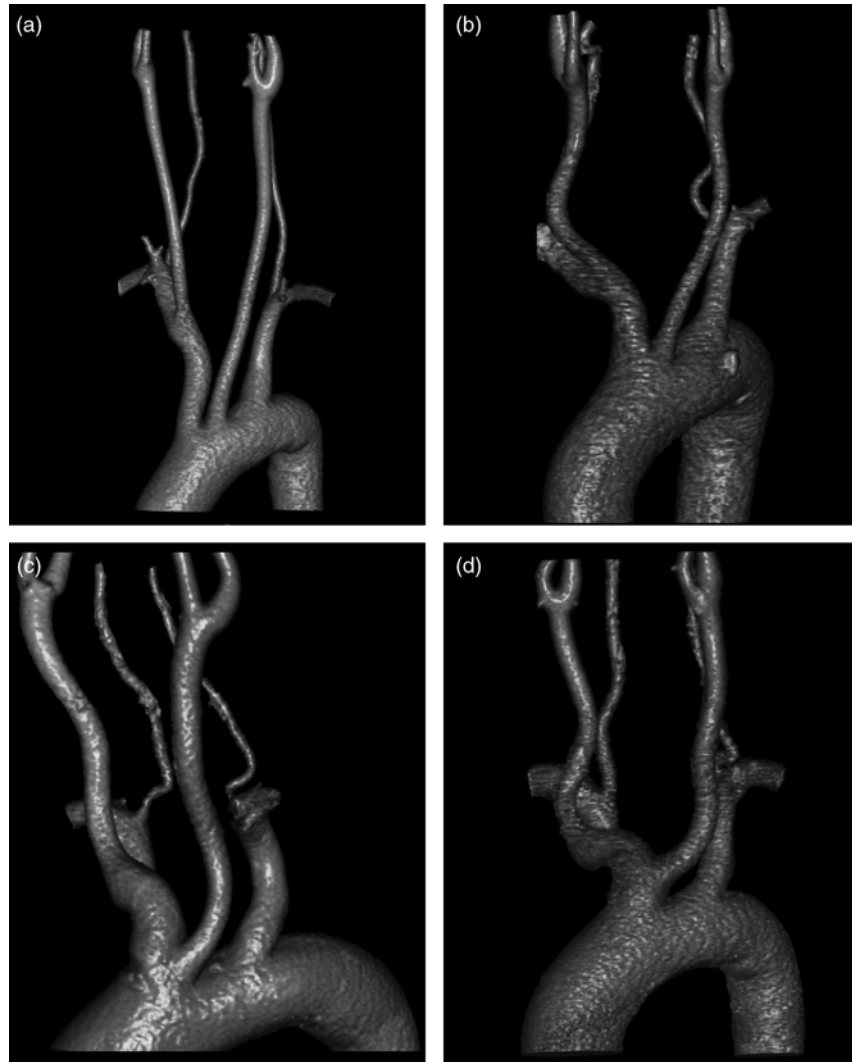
Contrast material assisted multidetector CT shows a fluid transition from (a) a separate (34-year-old woman) or (b) adjacent, V-shaped origin (51-year-old man) of the innominate and the left carotid artery to a true truncus bicaroticus in a 54-year-old man (c) and a 47-year-old man with an even more pronounced truncus bicaroticus (d)
